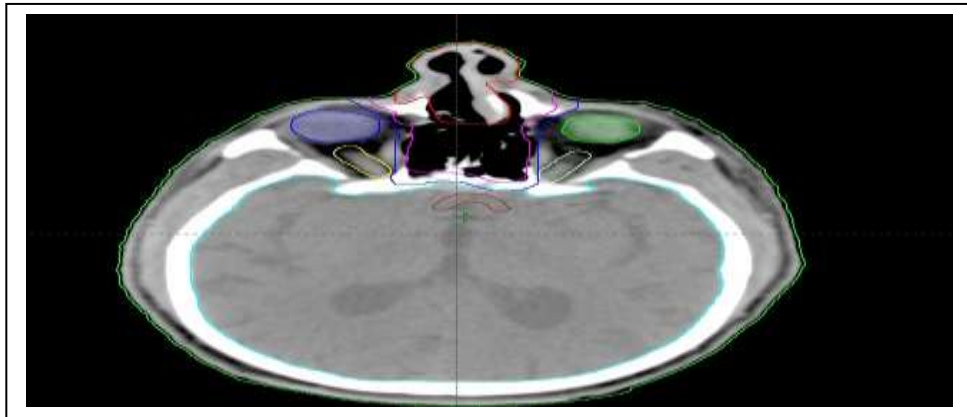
Axial section of a dosimetric CT scan displaying the target volumes for radiotherapy(GTV in red, CTV in pink, and PTV in blue)
